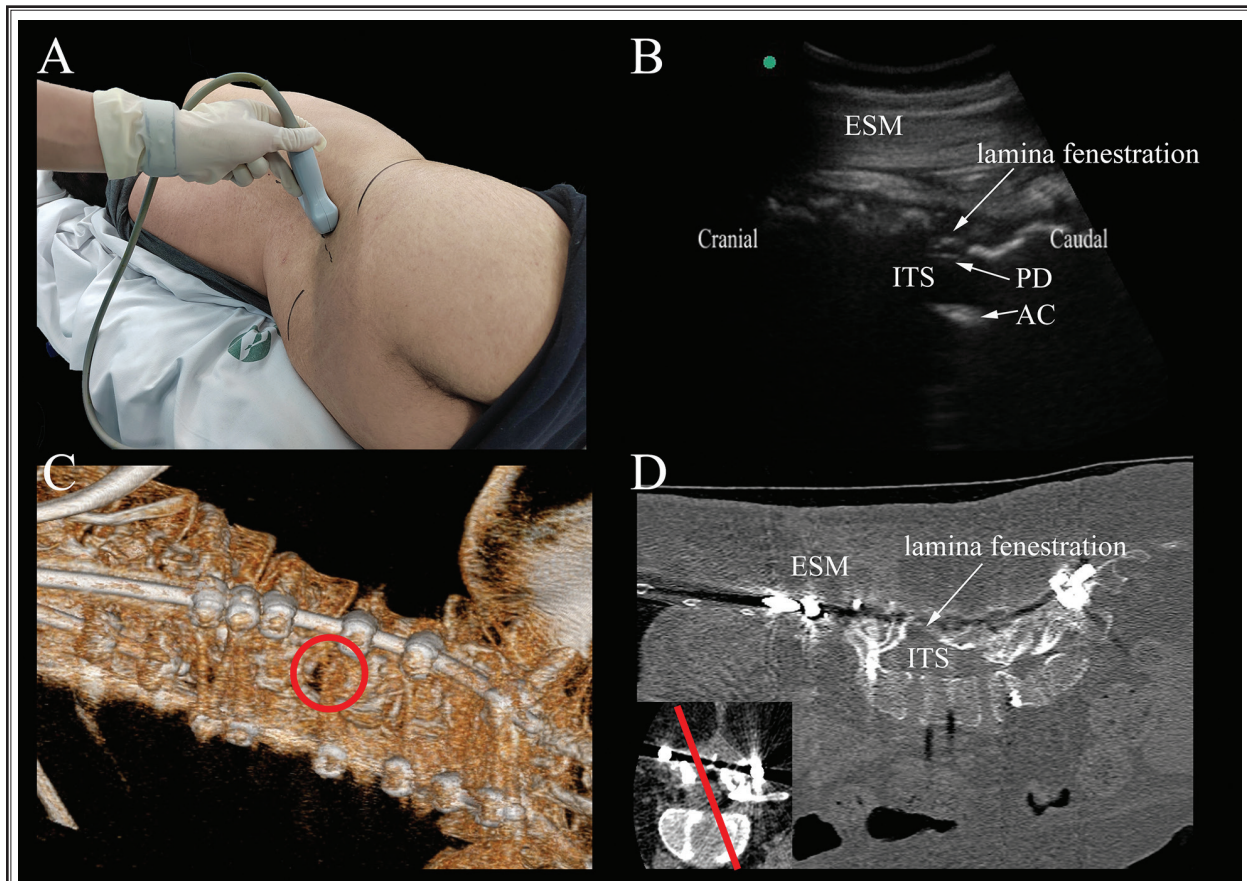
Paramedian sagittal oblique ( PMSO ) ultrasound view of one patient with spinal muscular atrophy and spine instrumentation
